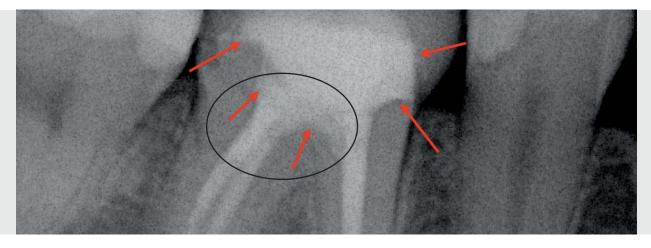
Final X-ray demonstrating the high radiopacity of Tetric EvoFlow and Tetric EvoCeram Bulk Fill
